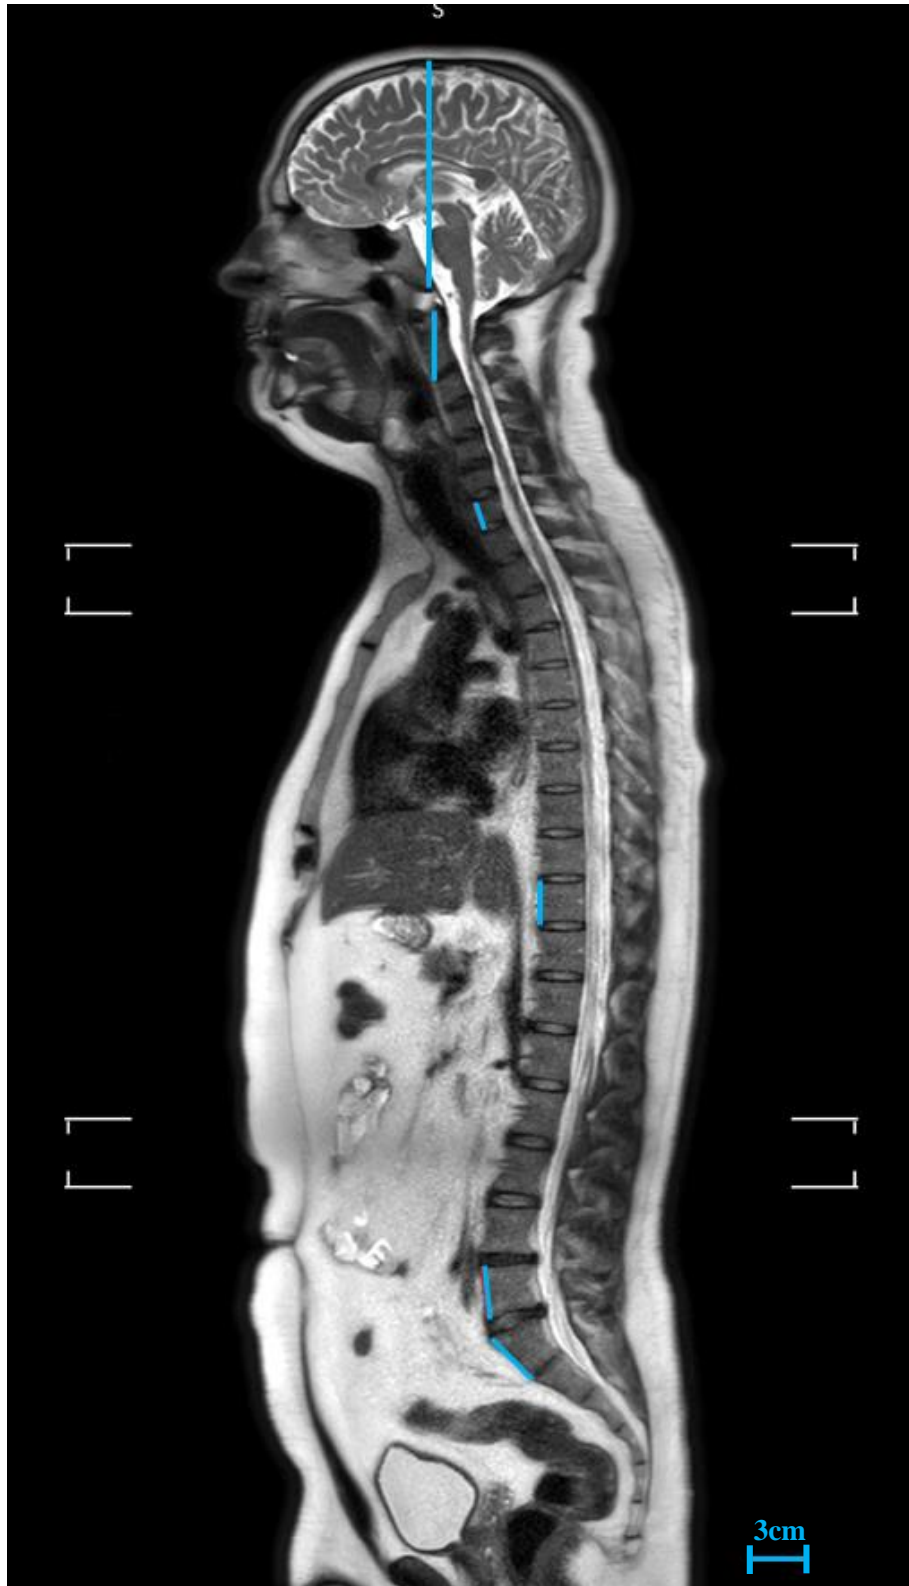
A sagittal MRI scan indicating a typical example of the skeletal measurements taken in this study of the cranium, C2 (axis), and the anterior body heights of C7, T10, L5, and S1 (Scale = 3 cm).
